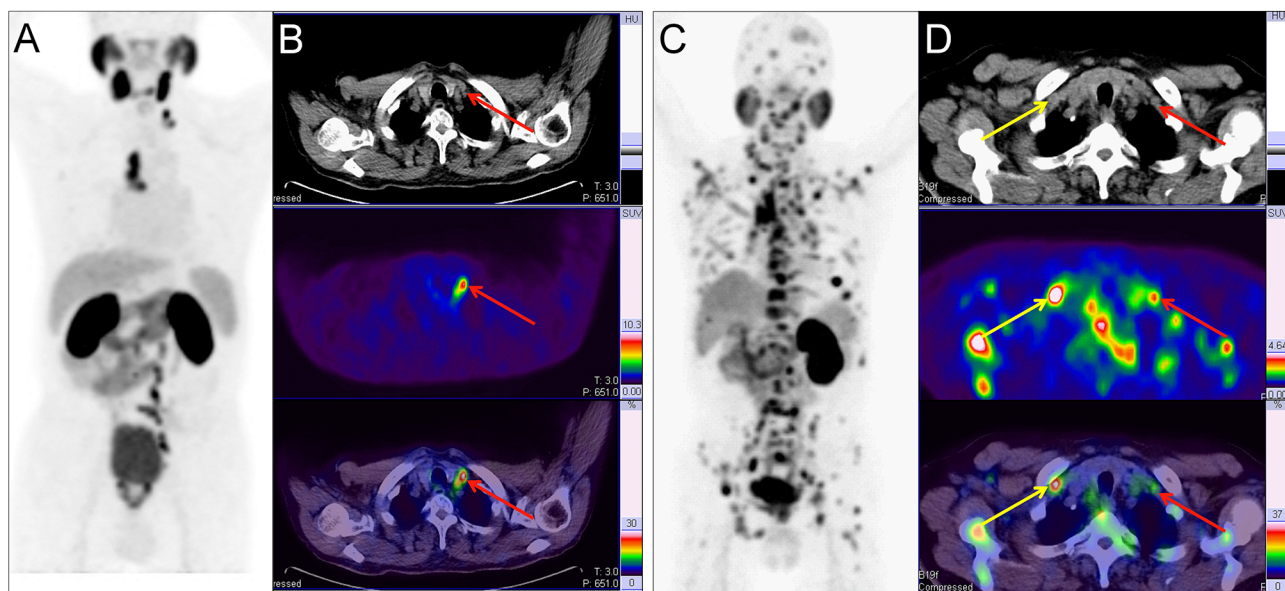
Two example PC patients with Virchow nodes. (A, B) ^{68}Ga -PSMA PET/CT results of a 76 y/o patient (T2cN1M1a, GS 4 + 4 = 8, tPSA 150.9 ng/ml). Virchow nodes (red arrow, SUV_{max} 8.42). After ^{68}Ga -PSMA PET/CT, LNMs were shown in the Virchow nodes, mediastinal lymph nodes, and retroperitoneal lymph nodes so RP with ePLND could be replaced by RT. (C, D) ^{68}Ga -PSMA PET/CT of a 73 y/o patient (pT4N1M1b; GS 5 + 4 = 9; tPSA 747.9 ng/ml). right supraclavicular LNMs (yellow arrow, SUV_{max} 7.89) and Virchow nodes (red arrow, SUV_{max} 2.98). In the first patient, the LNMs risks were 81.0%, 99.0%, and 70.0% according to the Briganti, MSKCC and Winter nomograms, respectively. The LNMs risk (>65%) indicated that the PC patients may have non-regional LNMs. After ^{68}Ga -PSMA PET/CT, the radiation scope of radiotherapy could be modified for more accurate location.
